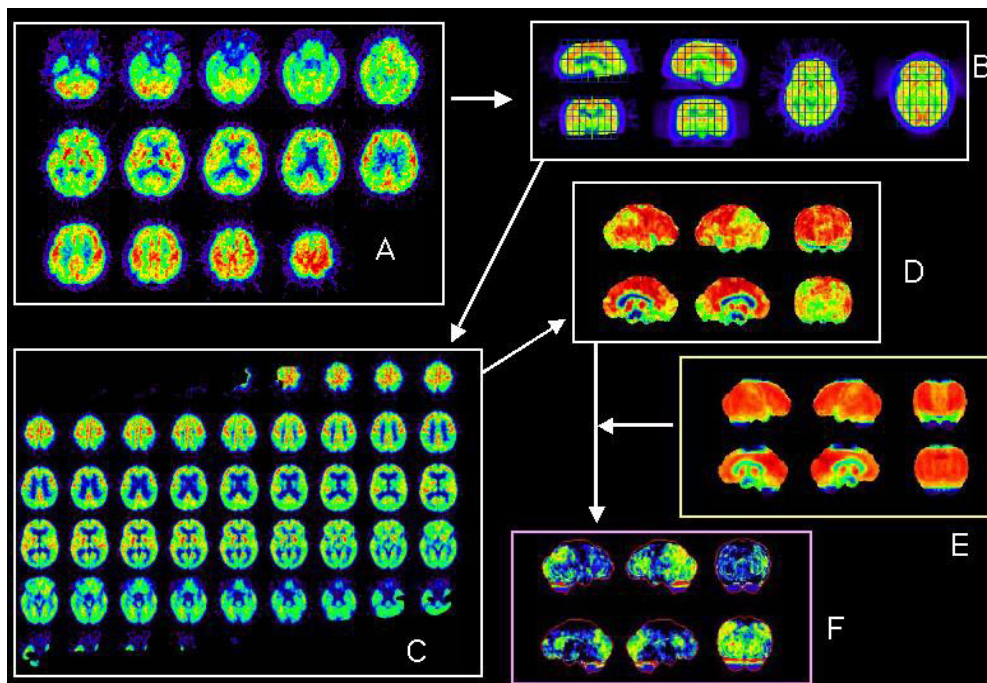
Process of 3D-SSP. A: original FDG-PET image of a patient with DLB. B: matching of the original image of the patient with DLB to a template image. C: anatomically standardized image of the patient with DLB. D: 3D-SSP image of the FDG-PET image of the patient with DLB. E: 3D-SSP image of the averaged FDG-PET image of 20 normal volunteers. F: Z-score map of the patient with DLB.
